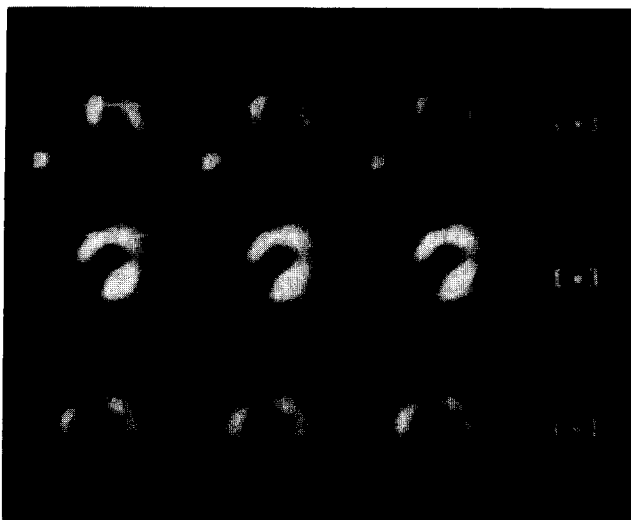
SPECT images after 4 h of a patient with reduced myocardial retention of [^{123}I]MIBG.
